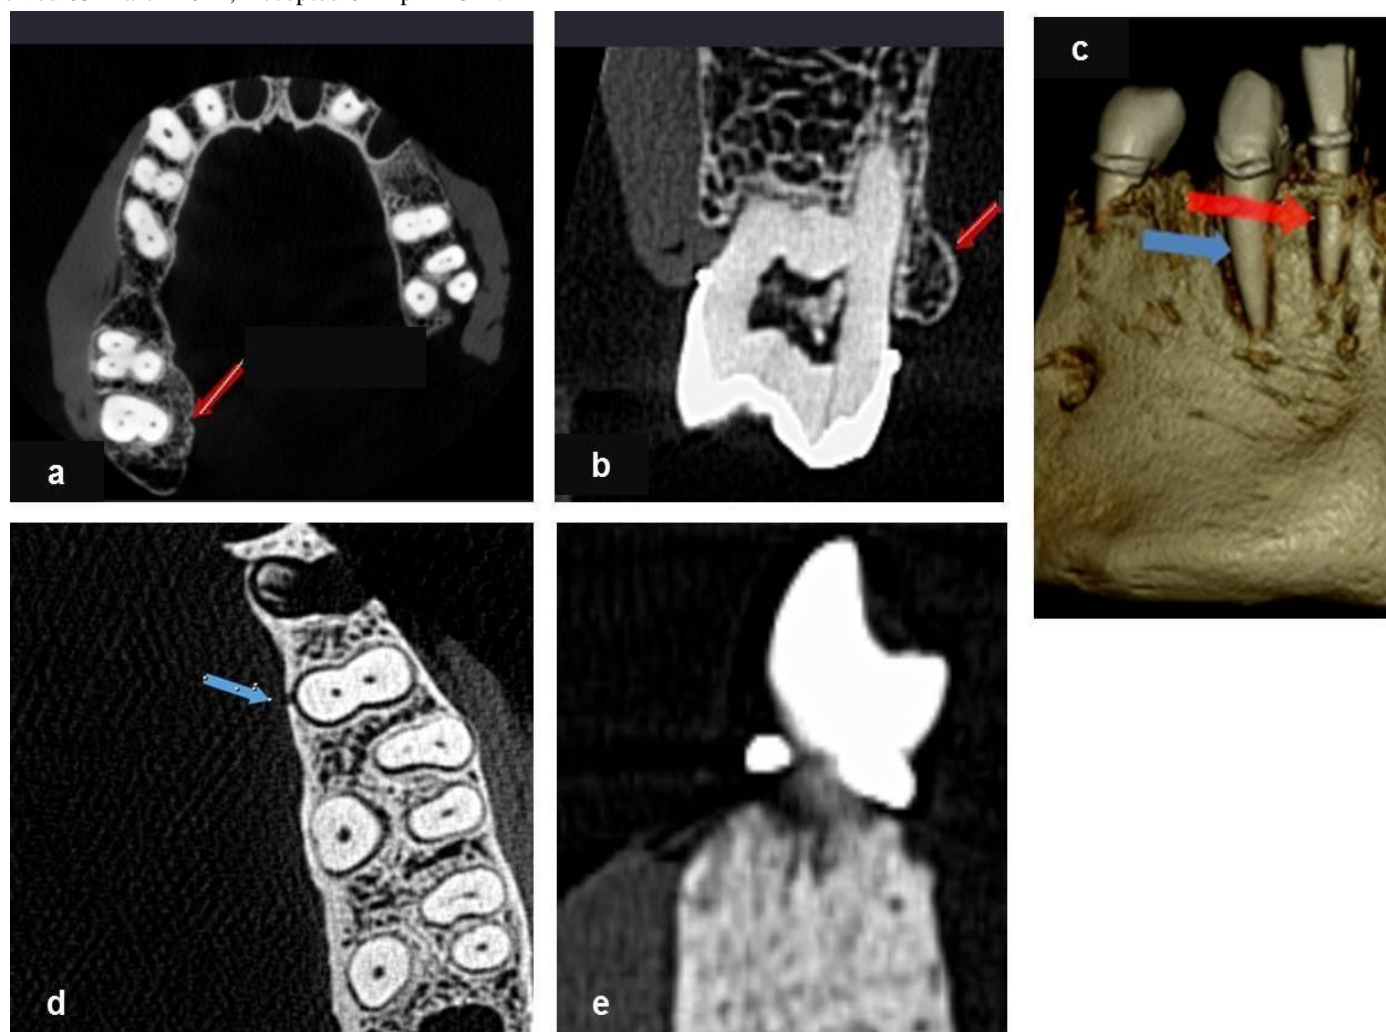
a: CBCT axial cut showing bulbous bone contour on the palatal aspect of the upper second and third right molars. b: CBCT coronal cut showing bulbous bone contour on the palatal aspect of the upper second right molar. c: CBCT volume rendering view showing Fenestration (red arrow) and dehiscence (blue arrow) on the labial surface of the teeth. d: CBCT axial cut showing dehiscence in the palatal aspect of upper right second premolar. e: CBCT Cross sectional cut viewing crater at distal aspect of lower right second premolar.
